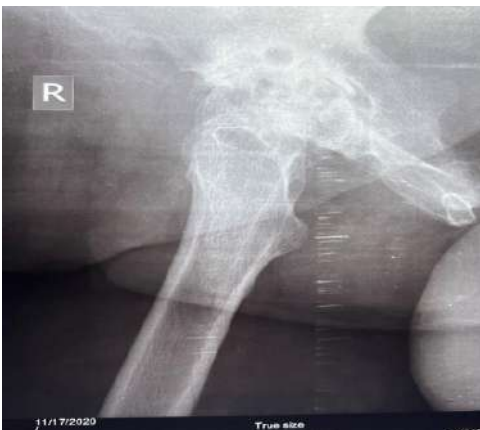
X-ray of the right hip joint (November2020)- showed features of degenerative changes.
